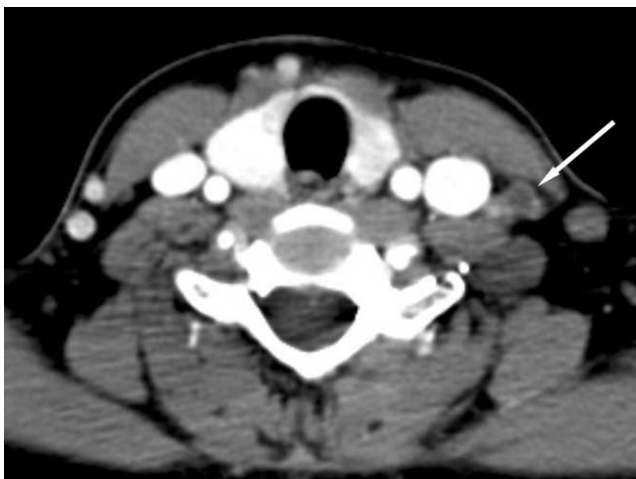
A 47-year-old man woman with papillary thyroid cancer in the left lobe of the thyroid gland. A CT demonstrates a small lymph node (arrow) with a focal cystic change in left level IV revealed to be a metastatic lymph node.
